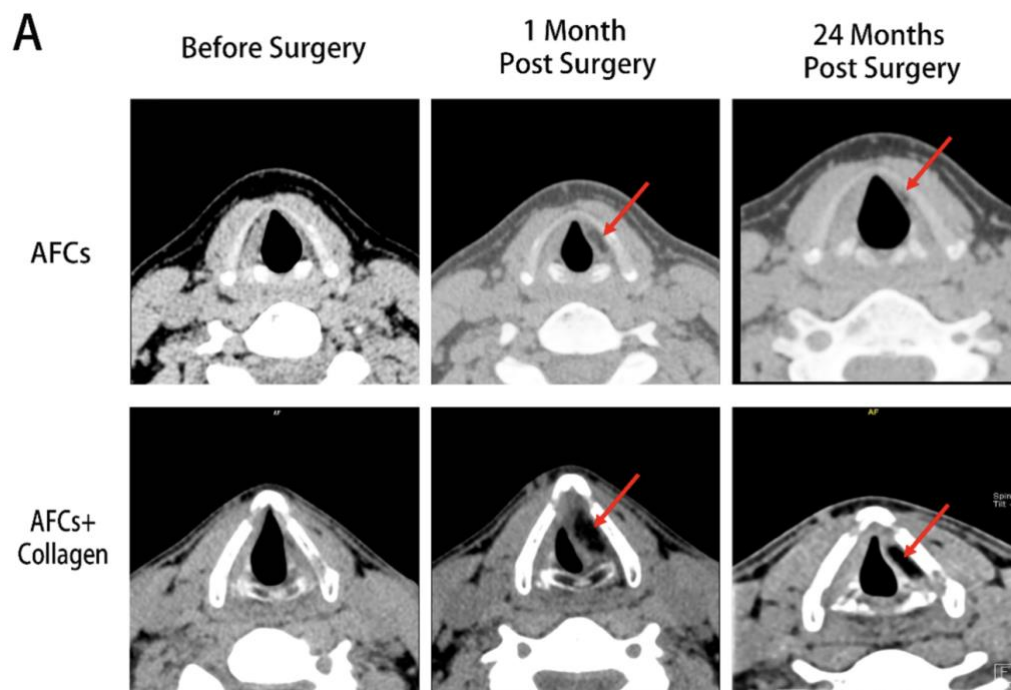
Representative axial CT images of the vocal folds
